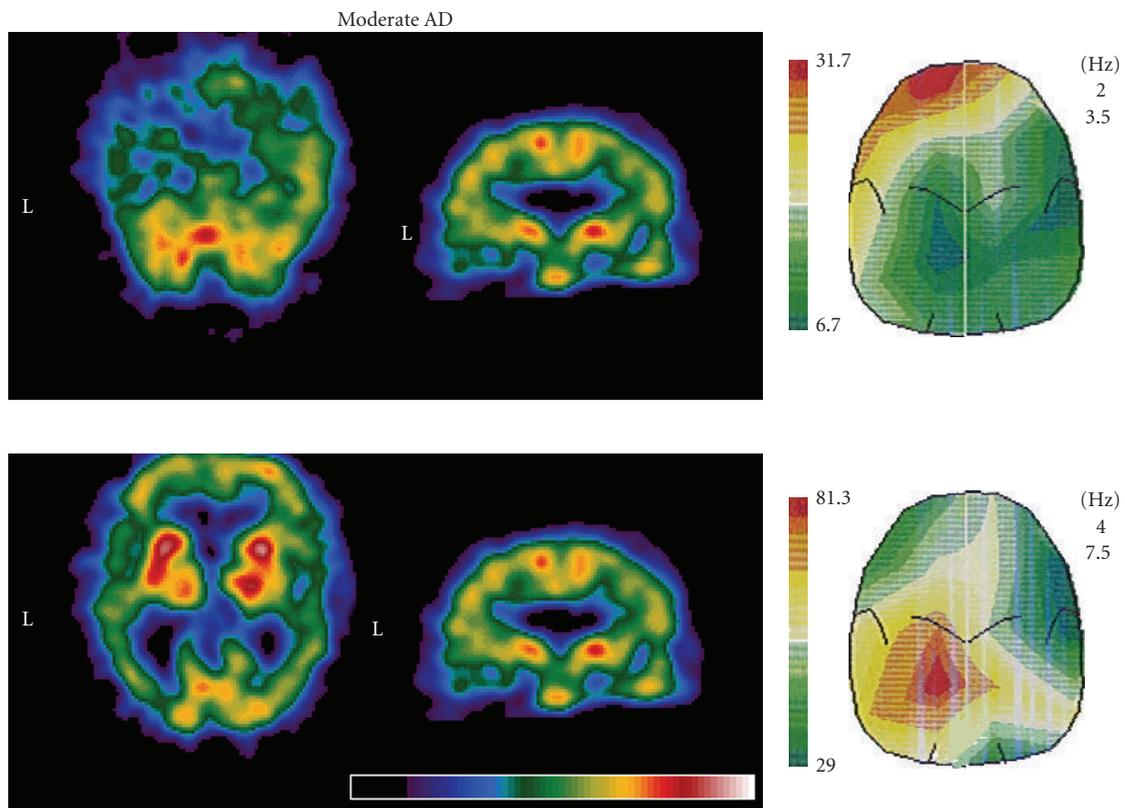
Sample of SPECT neuroimaging (Tc-99 HMPAO) and EEG brain mapping in a moderate AD patient. Topographic scalp distribution of the EEG power on the 2.0 to 3.5 Hz frequency band (top right) and 4.0 to 7.5 Hz frequency band (bottom right) is shown. For more details, see text.
